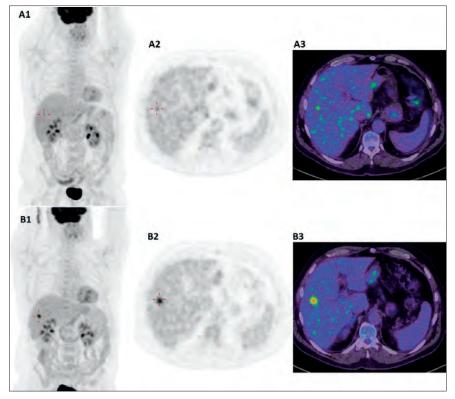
Whole body FDG-PET/CT in a 62-year-old patient after left hemicolectomy and chemotherapy for colon carcinoma. The patient presented with a single liver metastasis, which was treated with radiofrequency ablation. MIP view (A1) of follow-up FDG-PET/CT study; transaxial (A2) and fused (A3) views demonstrated a small area of doubtful significance in the right lobe of the liver (A1 - A3). A follow-up study 3 months later confirmed recurrence of the lesion in the liver (B1 - B3). The lesion is indicated with a red + sign.
